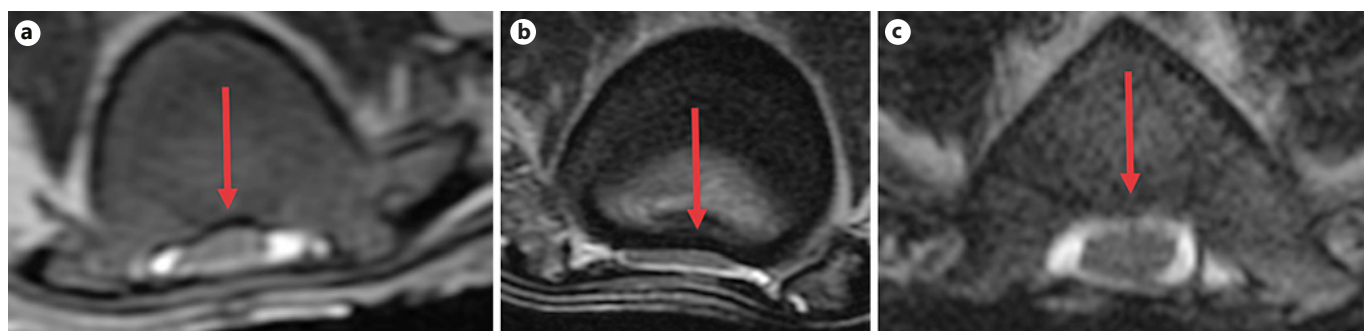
Spinal cord compression of lambs 1–3 on MRI at the maximum point of compression. Lamb 1 (a) and lamb 2 (b) had much less CSF surrounding the spinal cord at the maximum point of compression compared to lamb 3 (c). CSF, cerebral spinal fluid.
